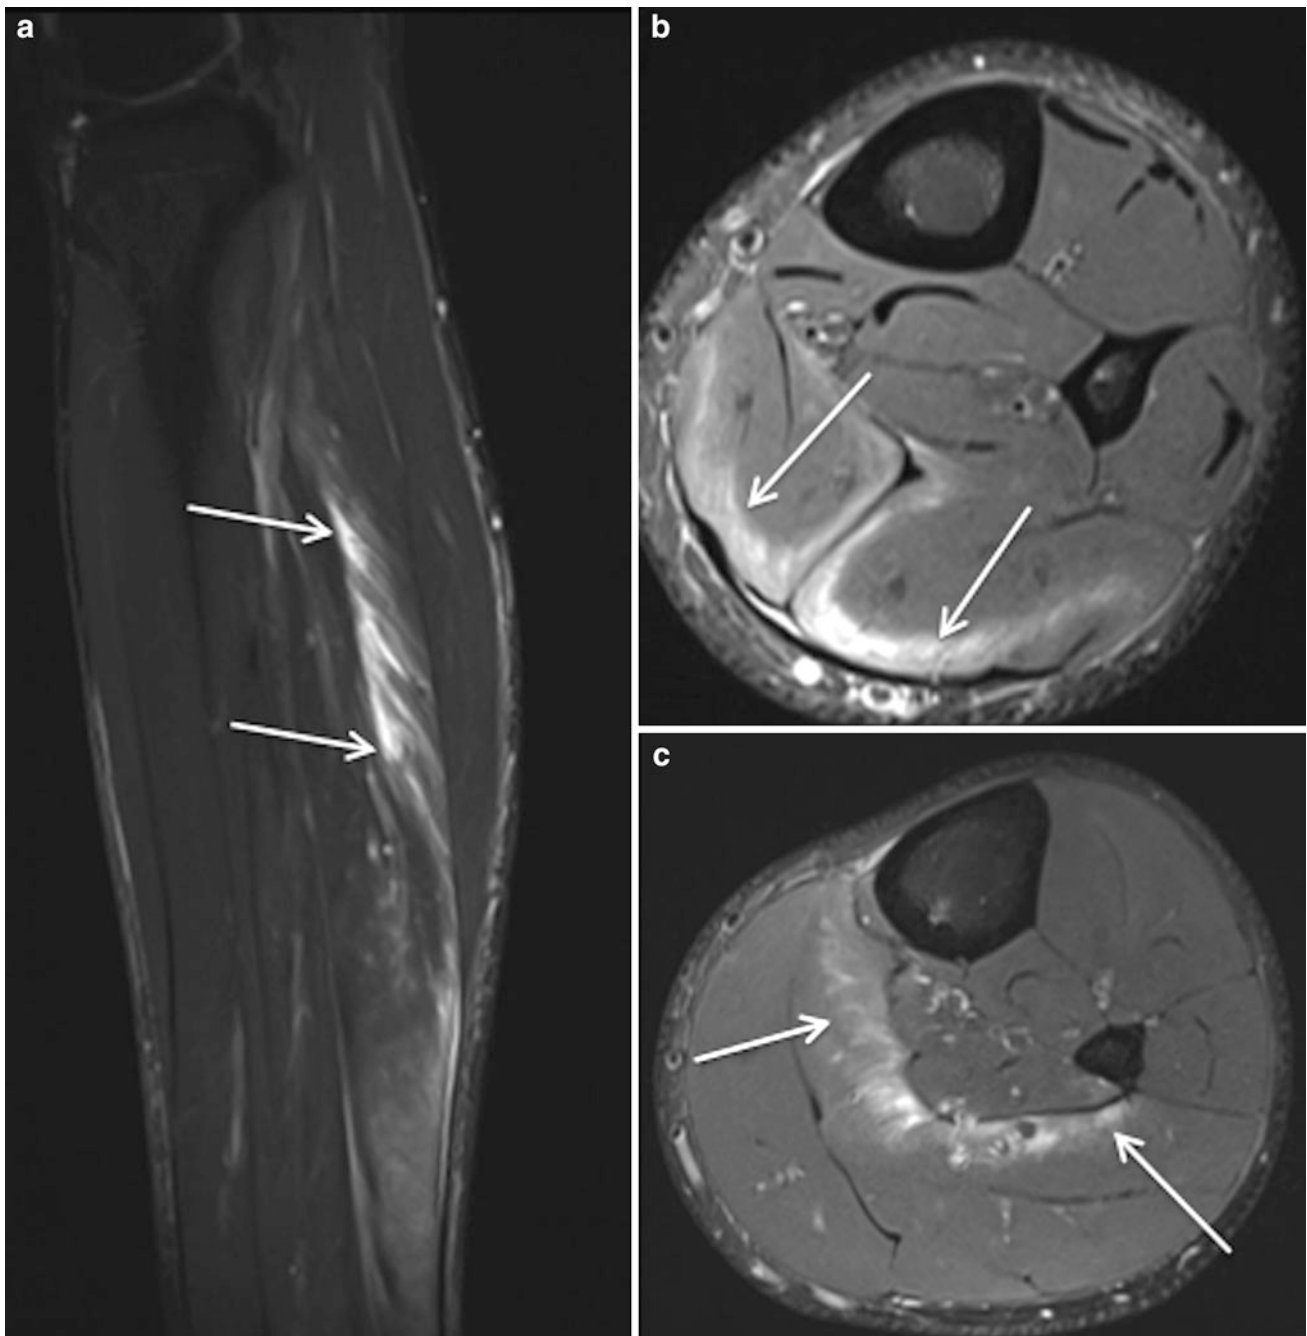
Sagittal STIR MR image (a) and axial proton density weighted MR images with fat saturation (b and c) demonstrate extensive post exercise oedema within the soleus muscle in an Australian Rules
